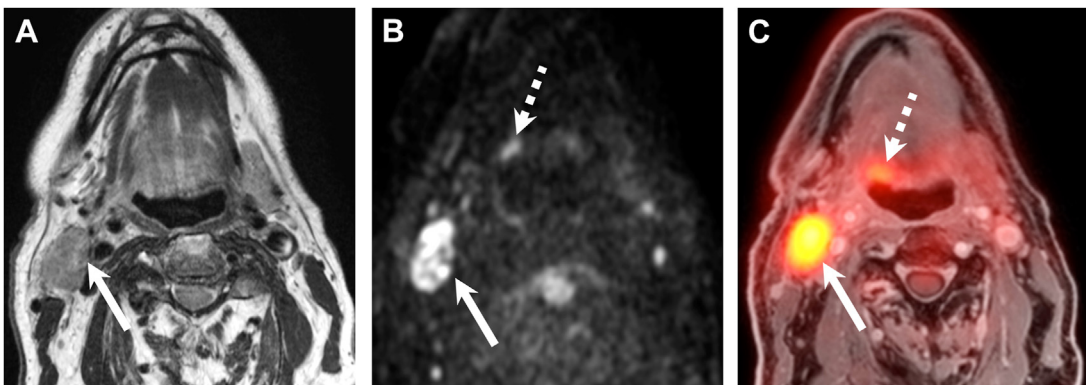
Unknown primary cancer detected on PET/MR imaging. (A) T2W image shows a large level II lymph node metastasis (*arrow*) in a 63-year-old man. Ultrasonography-guided fine needle aspiration cytology revealed p16 positive squamous cell carcinoma (SCC). (B) Corresponding b1000 image from DWI. (C) FDG PET fused with the fat-saturated T1W contrast-enhanced image obtained at the same level. The metastatic lymph node (*arrows*) is equally well seen in (A, B) and (C). The small base of the tongue tumor is detected on DWI and PET (*dashed arrows*). Note, however, improved lesion conspicuity on PET due to increased FDG uptake. Endoscopic biopsy-confirmed HPV-positive SCC.
